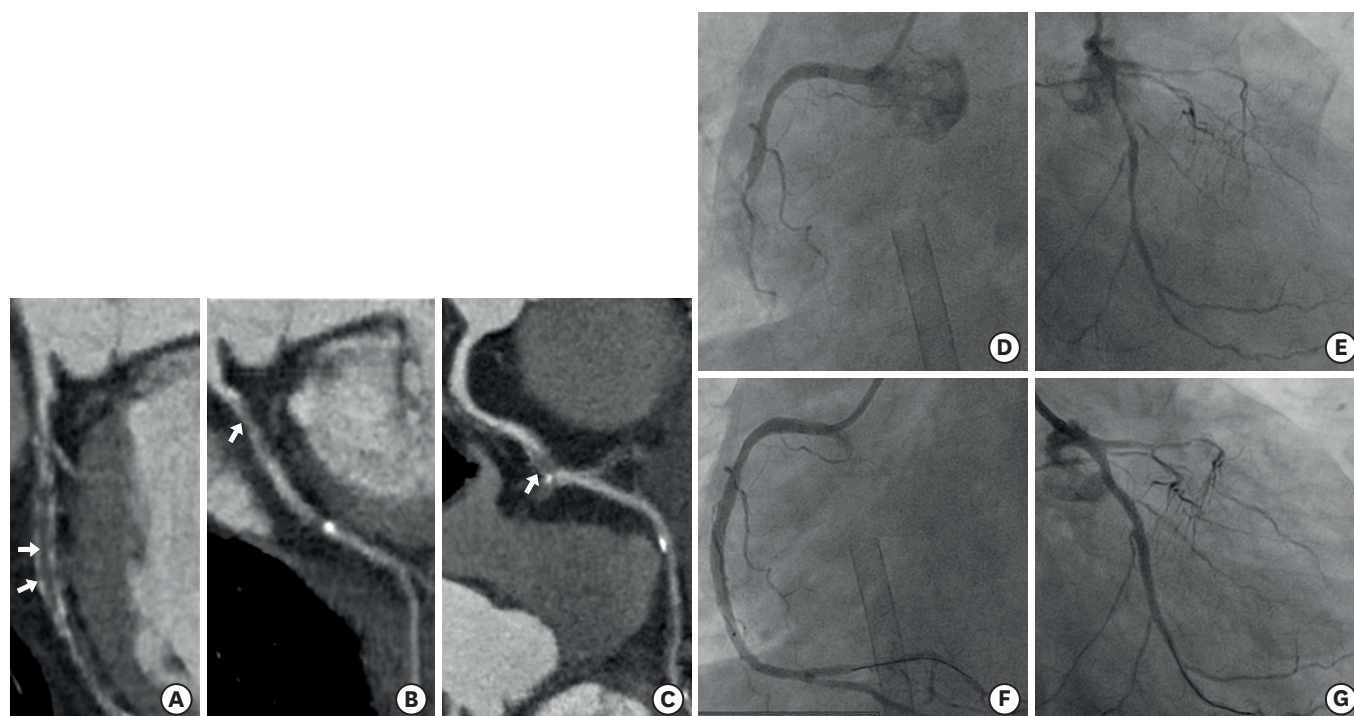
Coronary CT angiography and PCI for LCX coronary artery and RCA. (A) Total occlusion of the LAD coronary artery; (B) 80–90% severe stenosis of proximal to mid-LCX; (C) near-total occlusion of the mid-RCA; (D, E) PCI for LCX lesion; (F, G) PCI for RCA lesion.
